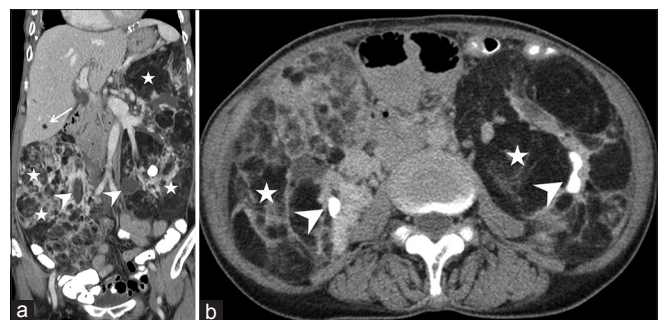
(a) Coronal reconstruction of contrast-enhanced computed tomography (CT) abdomen shows infiltrative fat containing giant masses (white asterisks) in retroperitoneum, replacing almost entire both kidneys. Renal pelvis is seen on either side (white arrowheads). There is a fat containing lesion in right lobe of liver (white arrow). (b) Axial CT image of delayed contrast study shows bilateral fatty angiomyolipomas (white asterisks) with excretory contrast in renal pelvis (white arrowheads)
